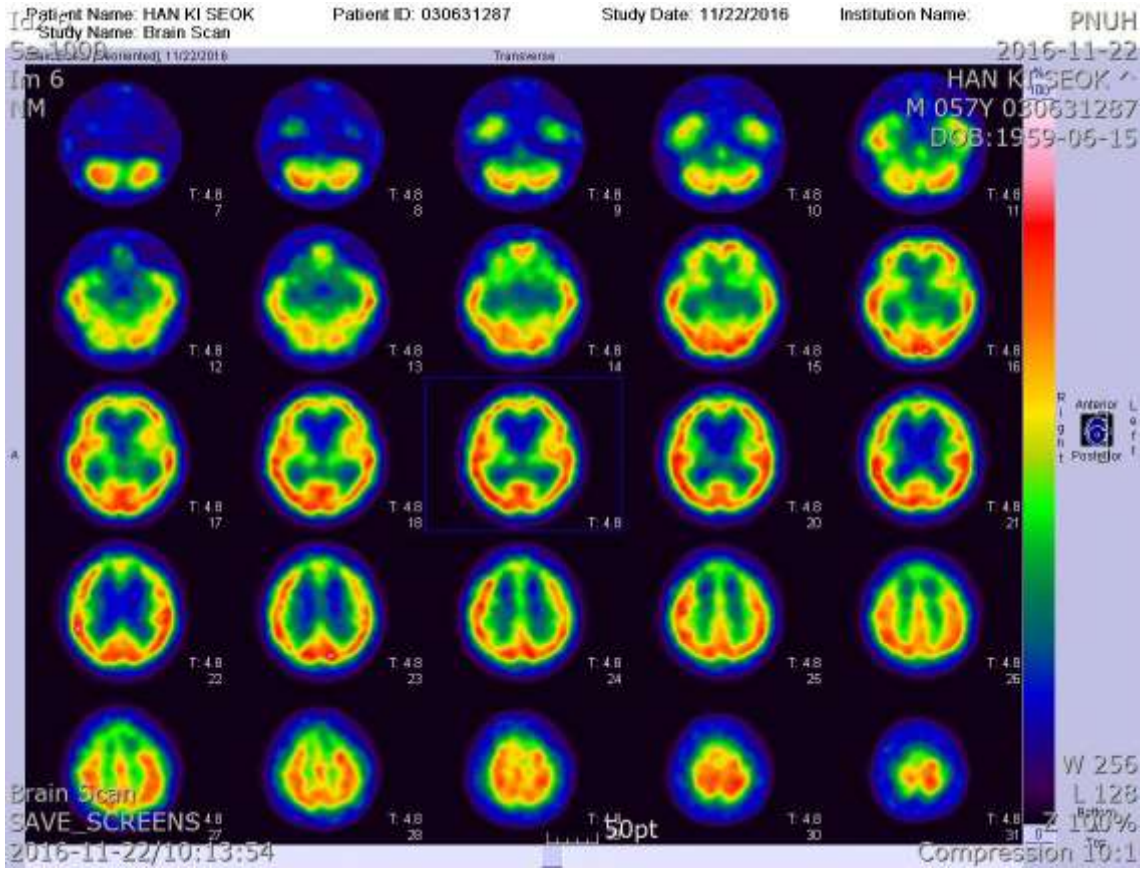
SPECT image showing moderately decreased perfusion at both basal ganglia.
